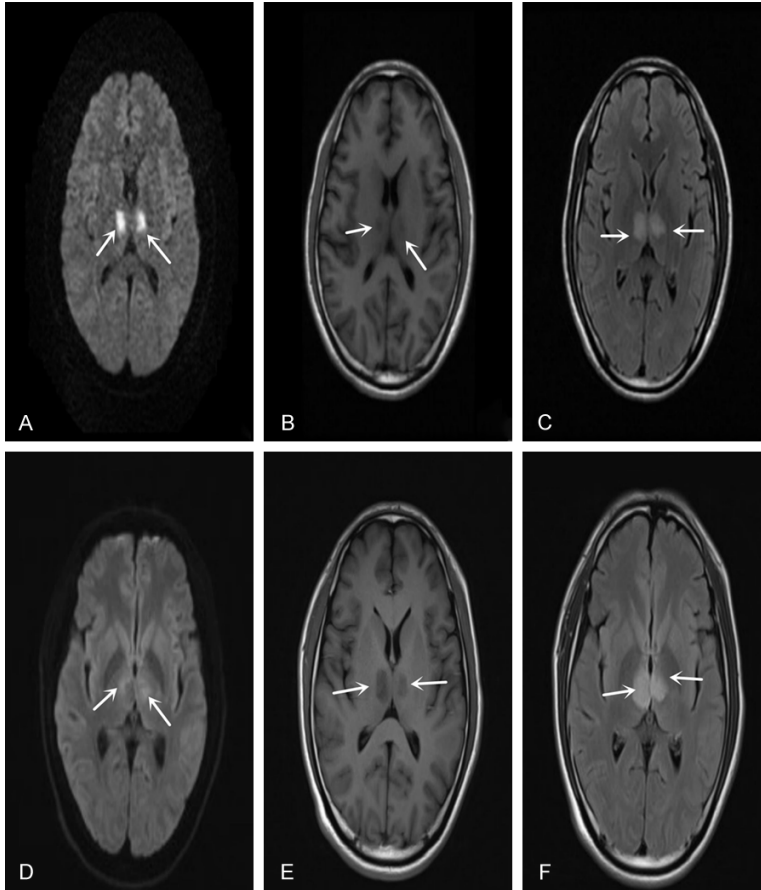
MRI and DWI imaging of the patient's head. A-C. Demonstrated areas of hyperintense signal in both thalamic on axial diffusion-weighted images were found in the brain. DWI showed symmetrical paramedian thalamic high signal intensity. D-F. After 1 week of treatment, the review of MRI showed that the DWI signal of bilateral thalamic lesions was reduced, which is shown by the arrow.
